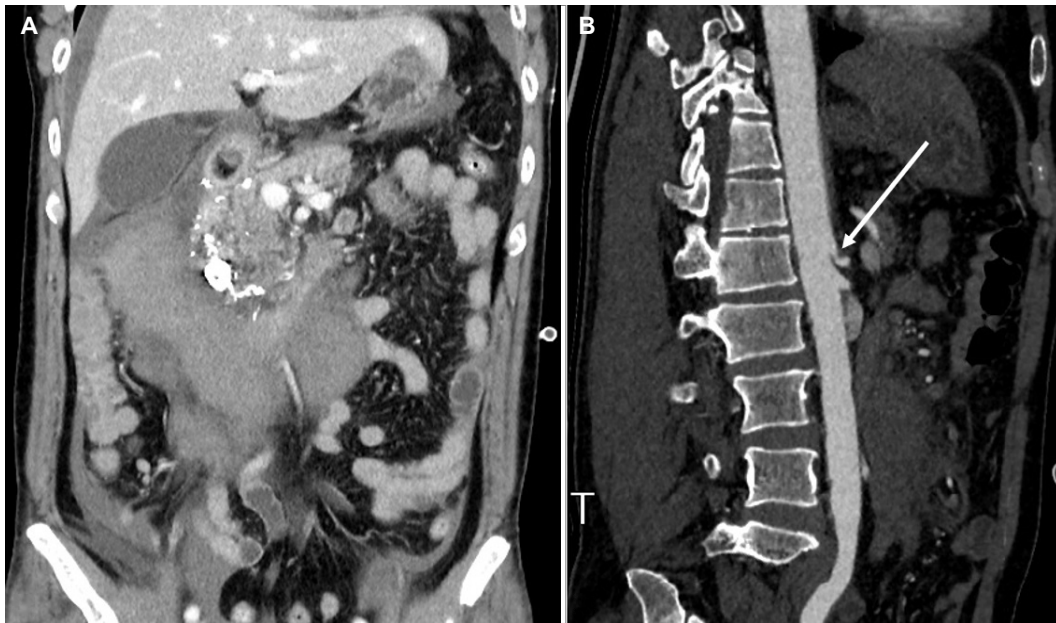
Vascular-aorta computed tomography angiography after 2 days of transarterial embolization. (A) Coronal image revealing slightly decreased size of hematoma in the anterior pararenal space. (B) Celiac artery stenosis is also apparent (arrow).
